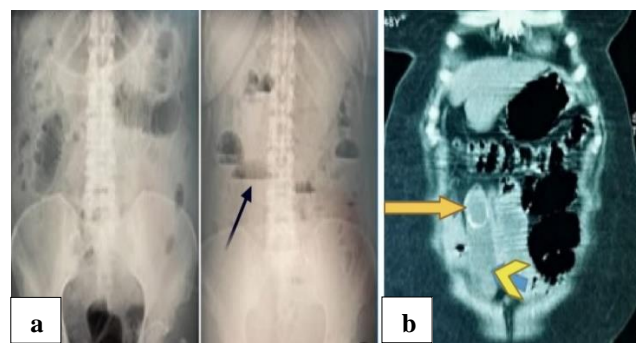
(a) Plain standing abdominal X-ray, dilatation of intestinal loops, hydro-aerial levels (arrow), and (b) abdominal tomography, gallstone of 2.5×2.4 cm embedded in jejunum (long arrow), dilatation of intestinal loops (arrowhead).
